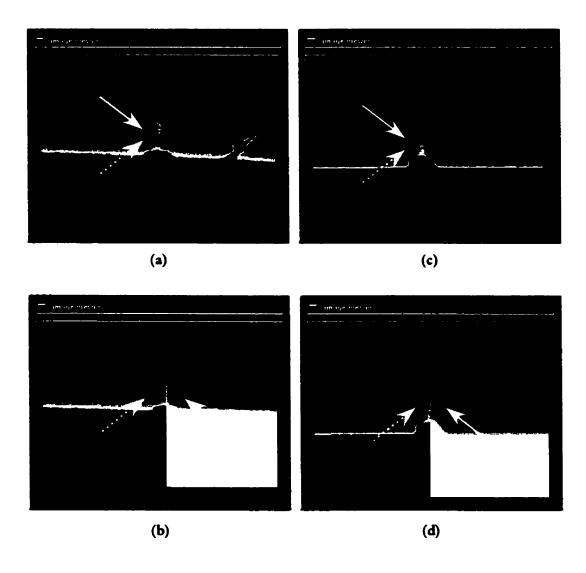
Ray-traced CT images and x-ray projection images. The ray-traced AP (a,b) and LAT (c,d) images (solid arrows) correlate very well visually with the AP (a,b) and LAT (c,d) x-ray projection images (dashed arrows).
